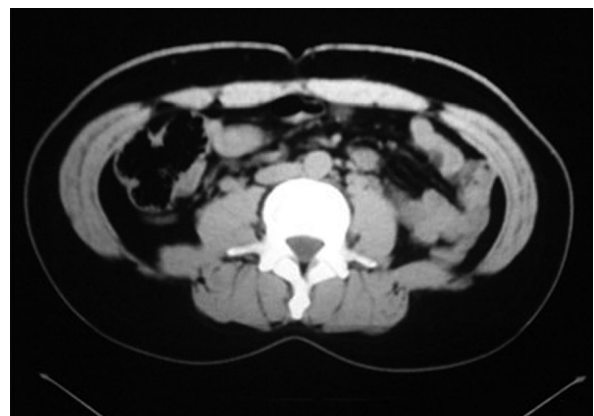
Post-operative CT scan of the abdominal compartment, lumbar section performed 1 year after the surgical procedure for other clinical reasons not related to our research.
